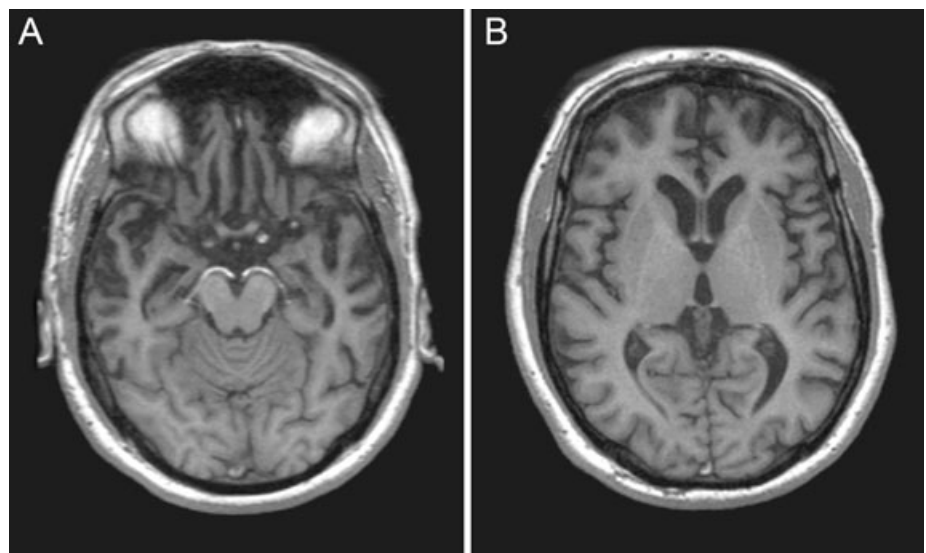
Magnetic resonance imaging. Moderate atrophy of the anterior temporal lobes in a patient with the P301L mutation in exon 10 of *Tau*.
